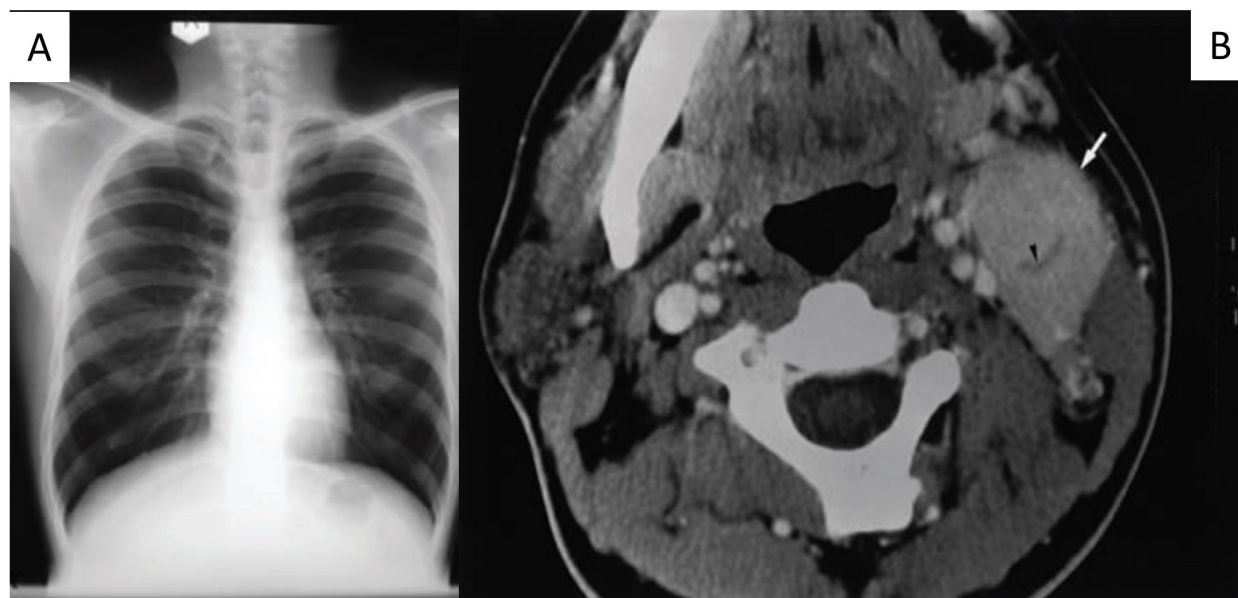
(A) Chest radiograph (posteroanterior view) showing normal lung fields and mediastinal contours, with no evidence of mediastinal widening, pulmonary lesion, or lymphadenopathy; (B) Axial contrast-enhanced computed tomography (CT) scan of the neck demonstrating an enlarged, well-enhancing left level II cervical lymph node (white arrow) with a central crescentic low-attenuation band (arrowhead), a radiological feature suggestive of a hypervascular lymphoid lesion.
